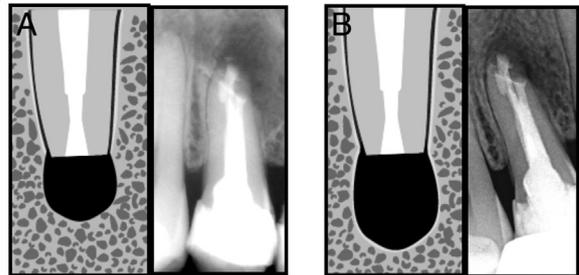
(A) The Molven radiographic criteria for evaluating teeth after EMS. Complete healing categories. (AA) The lamina dura is restored to the original width. (AB) The lamina dura is reconstituted but is less than 2 times the width along the resected root surface. (AC) The lamina dura is widened along the root-end filling material. (AD) Complete bone repair; however, the density of bone in the surgical site is not the same as the surrounding bone. No discernible lamina dura or periodontal ligament at the resected root surface suggesting ankylosis. (B) The Molven radiographic criteria for evaluating teeth after EMS. Incomplete healing categories. (B-A) The radiolucent area at follow-up has decreased; however, there is a dense radiolucency present that is asymmetric to the apex, sometimes disassociated from the apex, that presents often with a sunburst bone pattern. (B-B) A dense radiolucent area not in continuity with the periodontal ligament within the surgical site. (C) The Molven radiographic criteria for evaluating teeth after EMS. Uncertain healing categories. C-A represents the radiolucency as seen on an immediate postoperative radiograph and (C-B) represents the follow-up. The area has reduced significantly but is still larger than 2 times the original periodontal ligament space. (D) The Molven radiographic criteria for evaluating teeth after EMS. Unsatisfactory healing categories. D-A represents the radiolucency as seen on an immediate postoperative radiograph and D-B represents the follow-up. The area has enlarged in size or remains the same.
